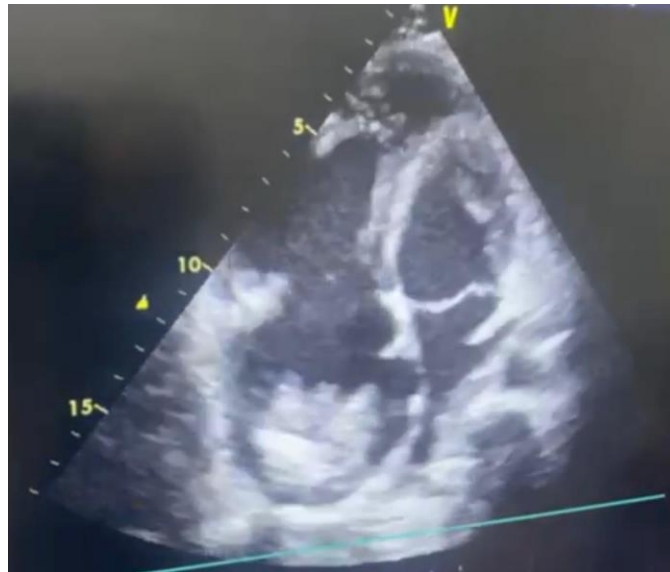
Echocardiography of the patient revealing a massive thrombus in the right atrium
